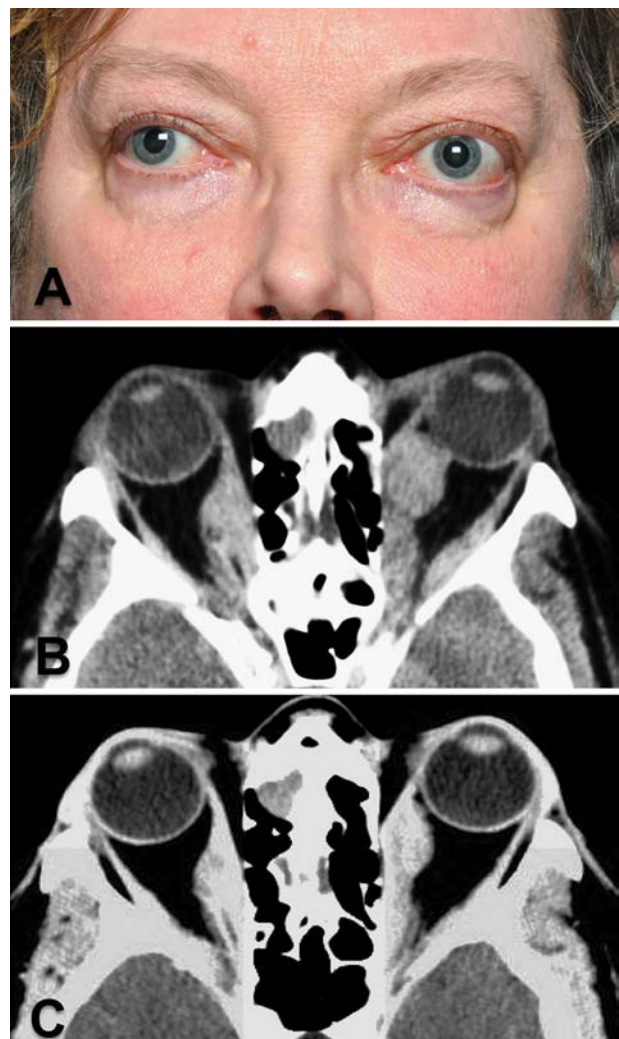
A, External photograph shows bilateral moderate eyelid swelling, bilateral asymmetric proptosis, right eye exotropia, and conjunctival hyperemia. B, Orbital computed tomography scan shows bilateral irregular enlargement of the right medial and left medial and lateral recti muscle bellies with tendon sparing. C, Reduction of the muscles enlargement after 9 weeks of orbital irradiation.
